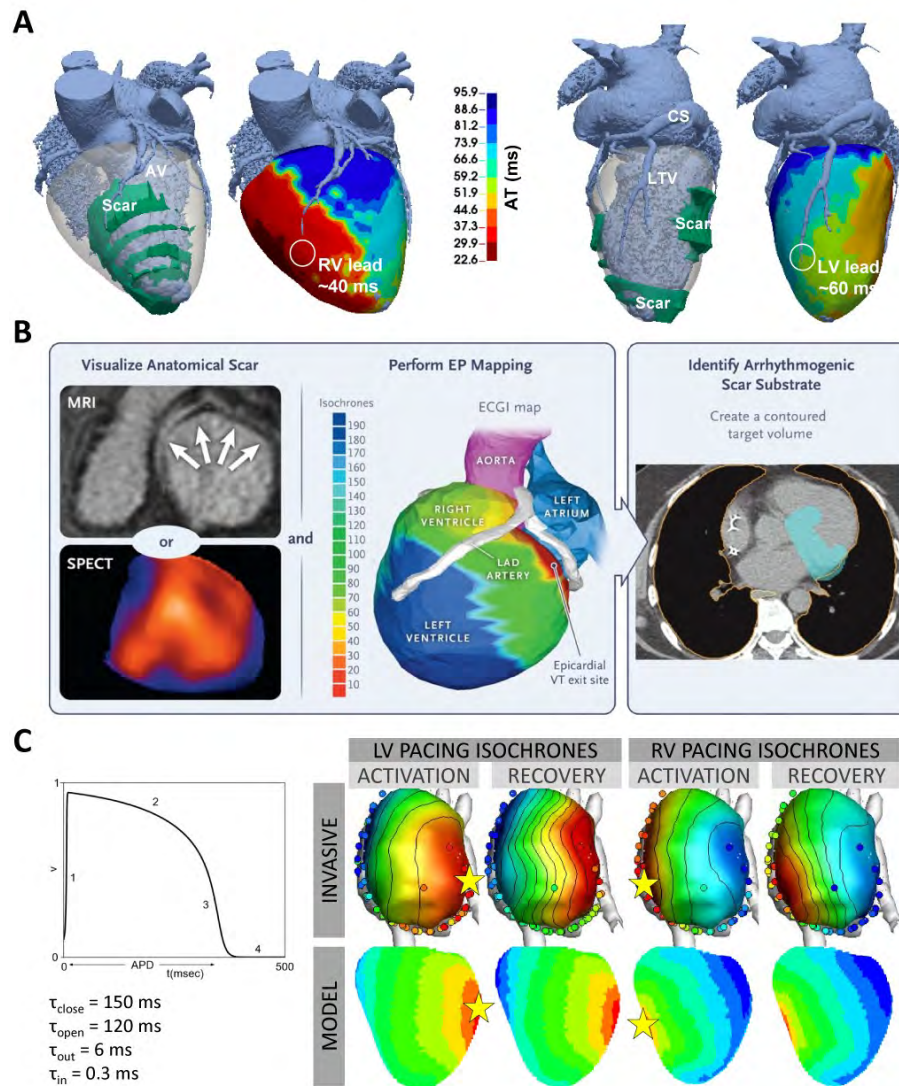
Image integration with ECGI. AV: anterior vein. RV: right ventricle. LV: left ventricle. CS: coronary sinus. LTV: lateral vein. LAD: left anterior descending. A, adapted from [46] with permission: optimizing lead placement in CRT by combining ECGI with MRI and CT scans. B, adapted from [48] with permission: Combining ECGI with anatomical imaging to guide catheter-free noninvasive cardiac radioablation for ventricular arrhythmias. C: Use of ECGI to personalize computational models to further perform risk stratification for SCD.
